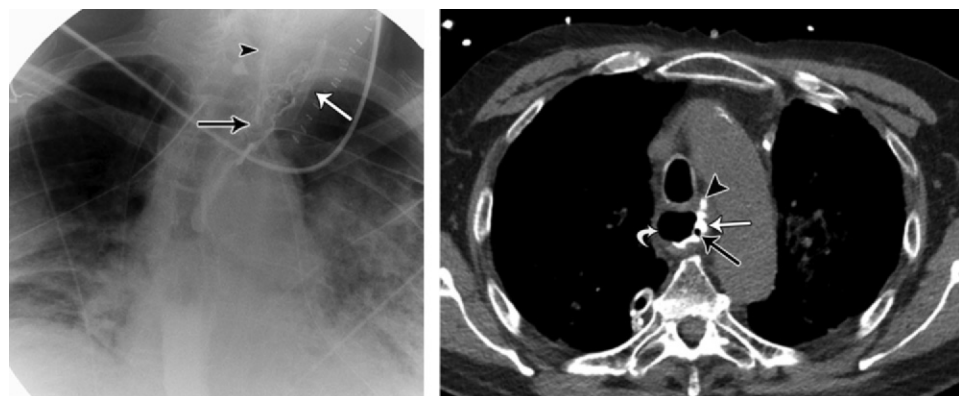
Redundant fundal tissue mimicking an anastomotic leak in a 74-year-old man after a McKeown esophagectomy for adenocarcinoma of the gastroesophageal junction. (a) Left posterior oblique esophagram of the upper thorax obtained on postoperative day 8 shows contrast agent tracking superolaterally toward the left neck incision and left neck surgical drain (white arrow), a finding suspicious for an anastomotic leak. Arrowhead = nasogastric tube, black arrow = cervical anastomosis. (b) Axial CT image (soft-tissue window) below the level of the esophagogastric anastomosis shows the gastric conduit (curved white arrow), nasogastric tube (black arrow), contrast agent (straight white arrow) surrounding the nasogastric tube, and suture line (arrowhead). (c) Axial CT image (soft-tissue window) at the level of the anastomosis shows the nasogastric tube (black arrow), suture line (arrowhead), and contrast agent (white arrow) surrounding the nasogastric tube within the conduit. (d) Axial CT image (soft-tissue window) above the level of the anastomosis shows contrast agent (white arrow) lateral to the nasogastric tube (black arrow) on the left within redundant fundal tissue, as evidenced by the suture line (arrowhead) alongside the redundant fundus.
